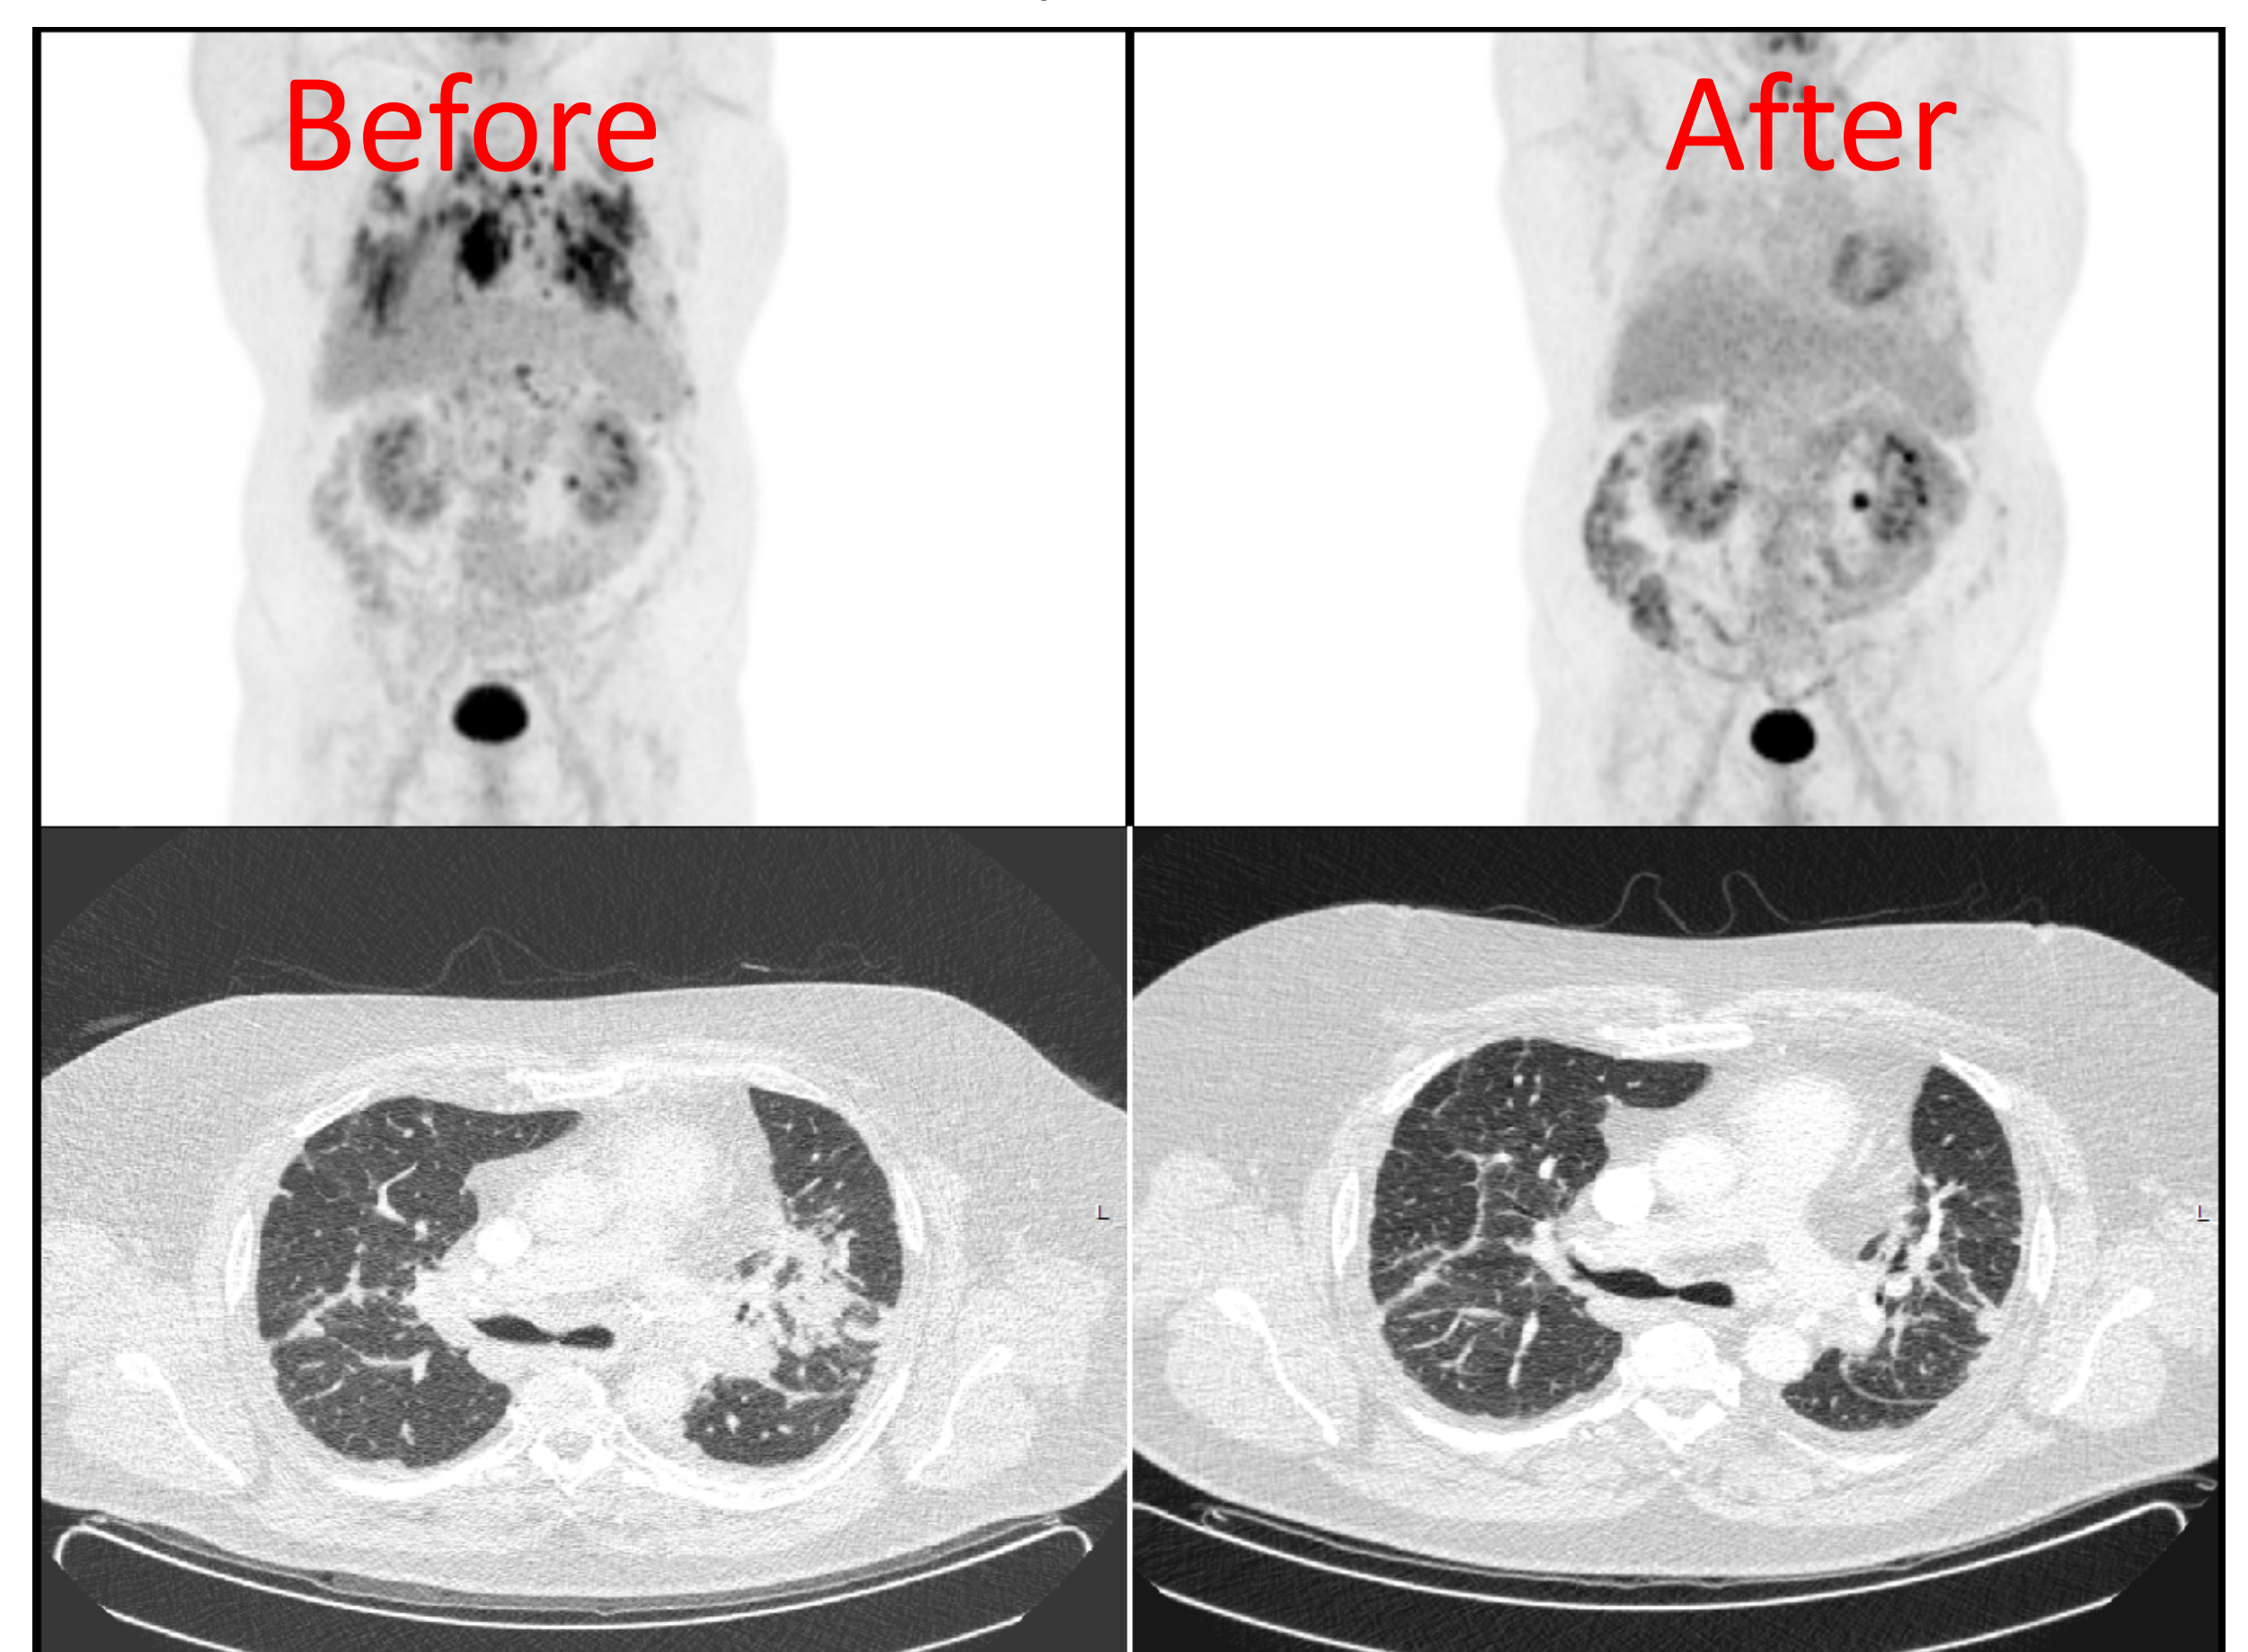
PET and HRCT scans before and after 7 months of infliximab therapy. Left: PET (above) and HRCT scan (below) 2 months before the start of infliximab. At this time point the patients was on azathioprine therapy for 8 months and prednisone therapy was stopped for 14 months . Right: PET (above) and HRCT scan (below) after 7 months of infliximab therapy showing decrease of consolidations.
